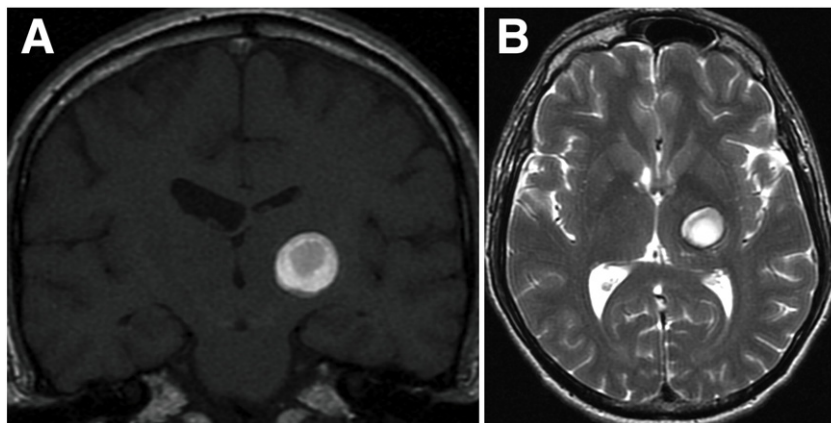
MRI at presentation following first symptomatic hemorrhage. T1 (A) coronal and T2 (B) axial MRI demonstrating a 1.72×1.96 cm well-circumscribed lesion and associated blood products consistent with a hemorrhagic cavernoma. The cavernoma is centered in the lateral left thalamus and posterior limb of the internal capsule.
